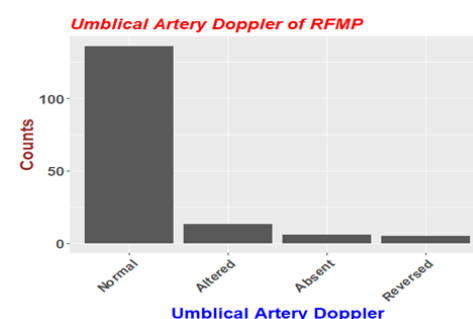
Frequency of umbilical artery Doppler abnormalities
